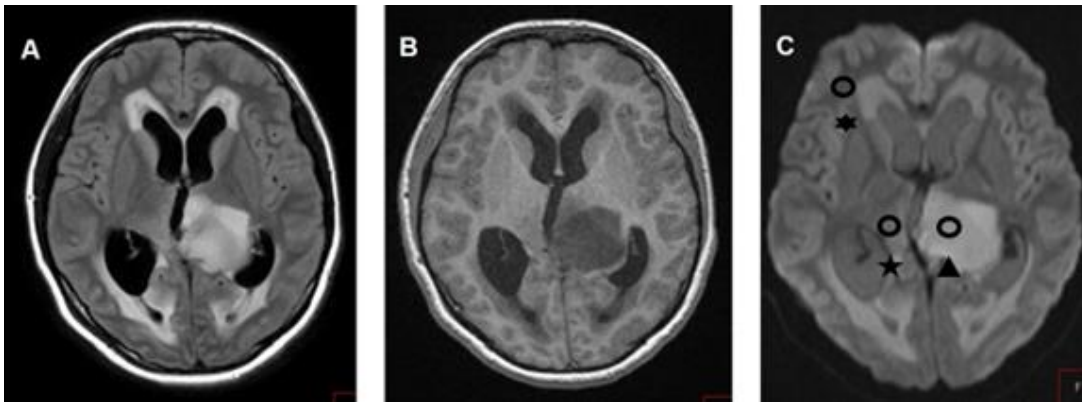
Measuring signal intensities on DWI, with a tumor in the left thalamus (A, B). In order to obtain DWI values (C), three ROI's (black circles) are placed at the brightest solid portion of the tumor on DWI (\blacktriangle), at the normal-appearing white matter of the frontal lobe (\star), and at the normal-appearing homologous area (\star) of tumor ROI in the contralateral hemisphere on the axial DWI image. (Method adapted from Wu CC, et al., 2012) [4]
